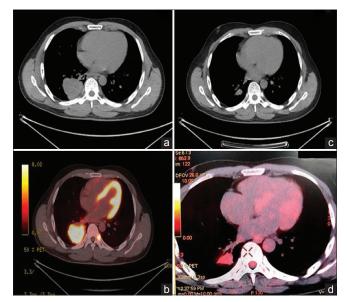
(a) Initial computed tomography scan of the patient at presentation showing an irregularly marginated mix-density lesion involving the posteromedial basal segments of the right lower lobe. (b) Initial positron emission tomography scan image showing the lung lesion. (c) Computed tomography scan 3 months after starting crizotinib showing significant resolution of the lung lesion. (d) Positron emission tomography scan also showing similar resolution of the pulmonary lesion
